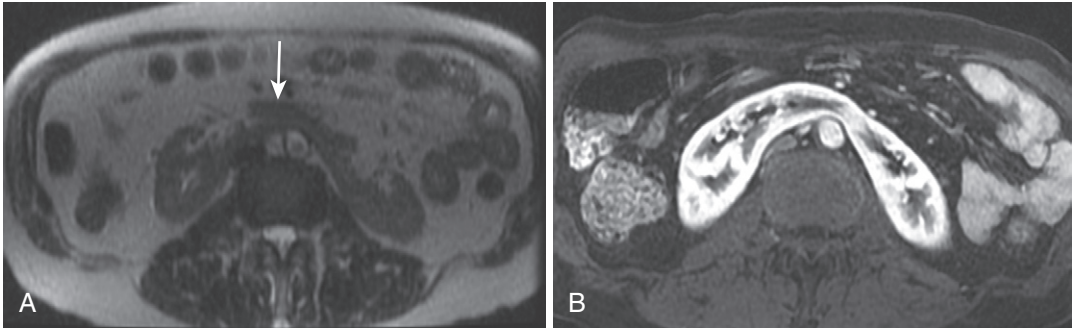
Horseshoe kidney. A, The axial T2-weighted image shows midline fusion of the lower renal poles (*arrow*) ventrally across the midline, anterior to the aorta. B, The corresponding arterial phase postcontrast image depicts characteristic corticomedullary enhancement of the fused renal mass.
